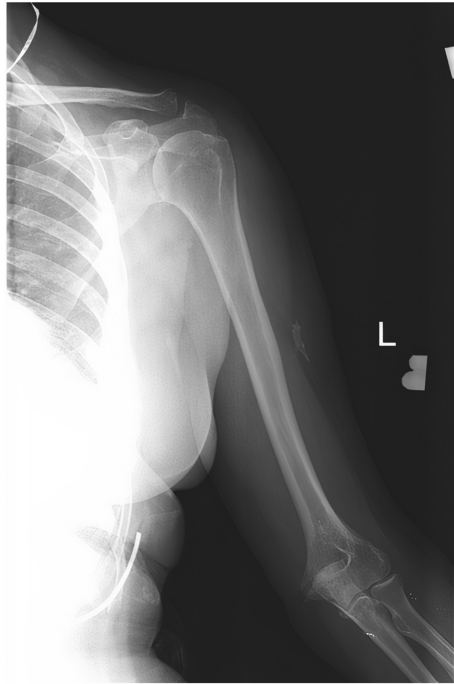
Radiograph of dense calcinosis in a burn scar of the left upper extremity.
